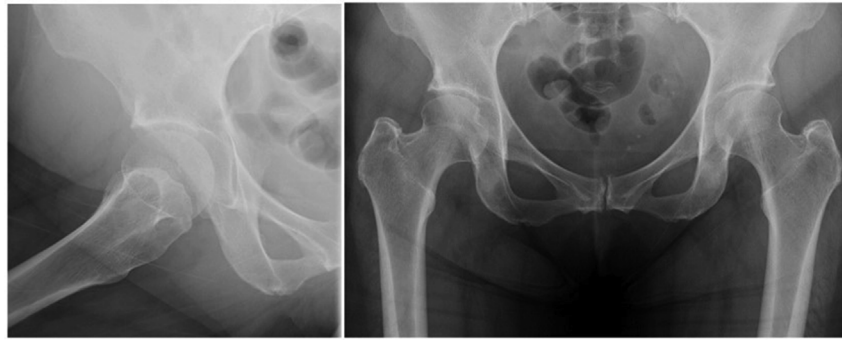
Plain radiograph for case 1, with an area of visible calcification on the edge of the roof of the right acetabulum.
